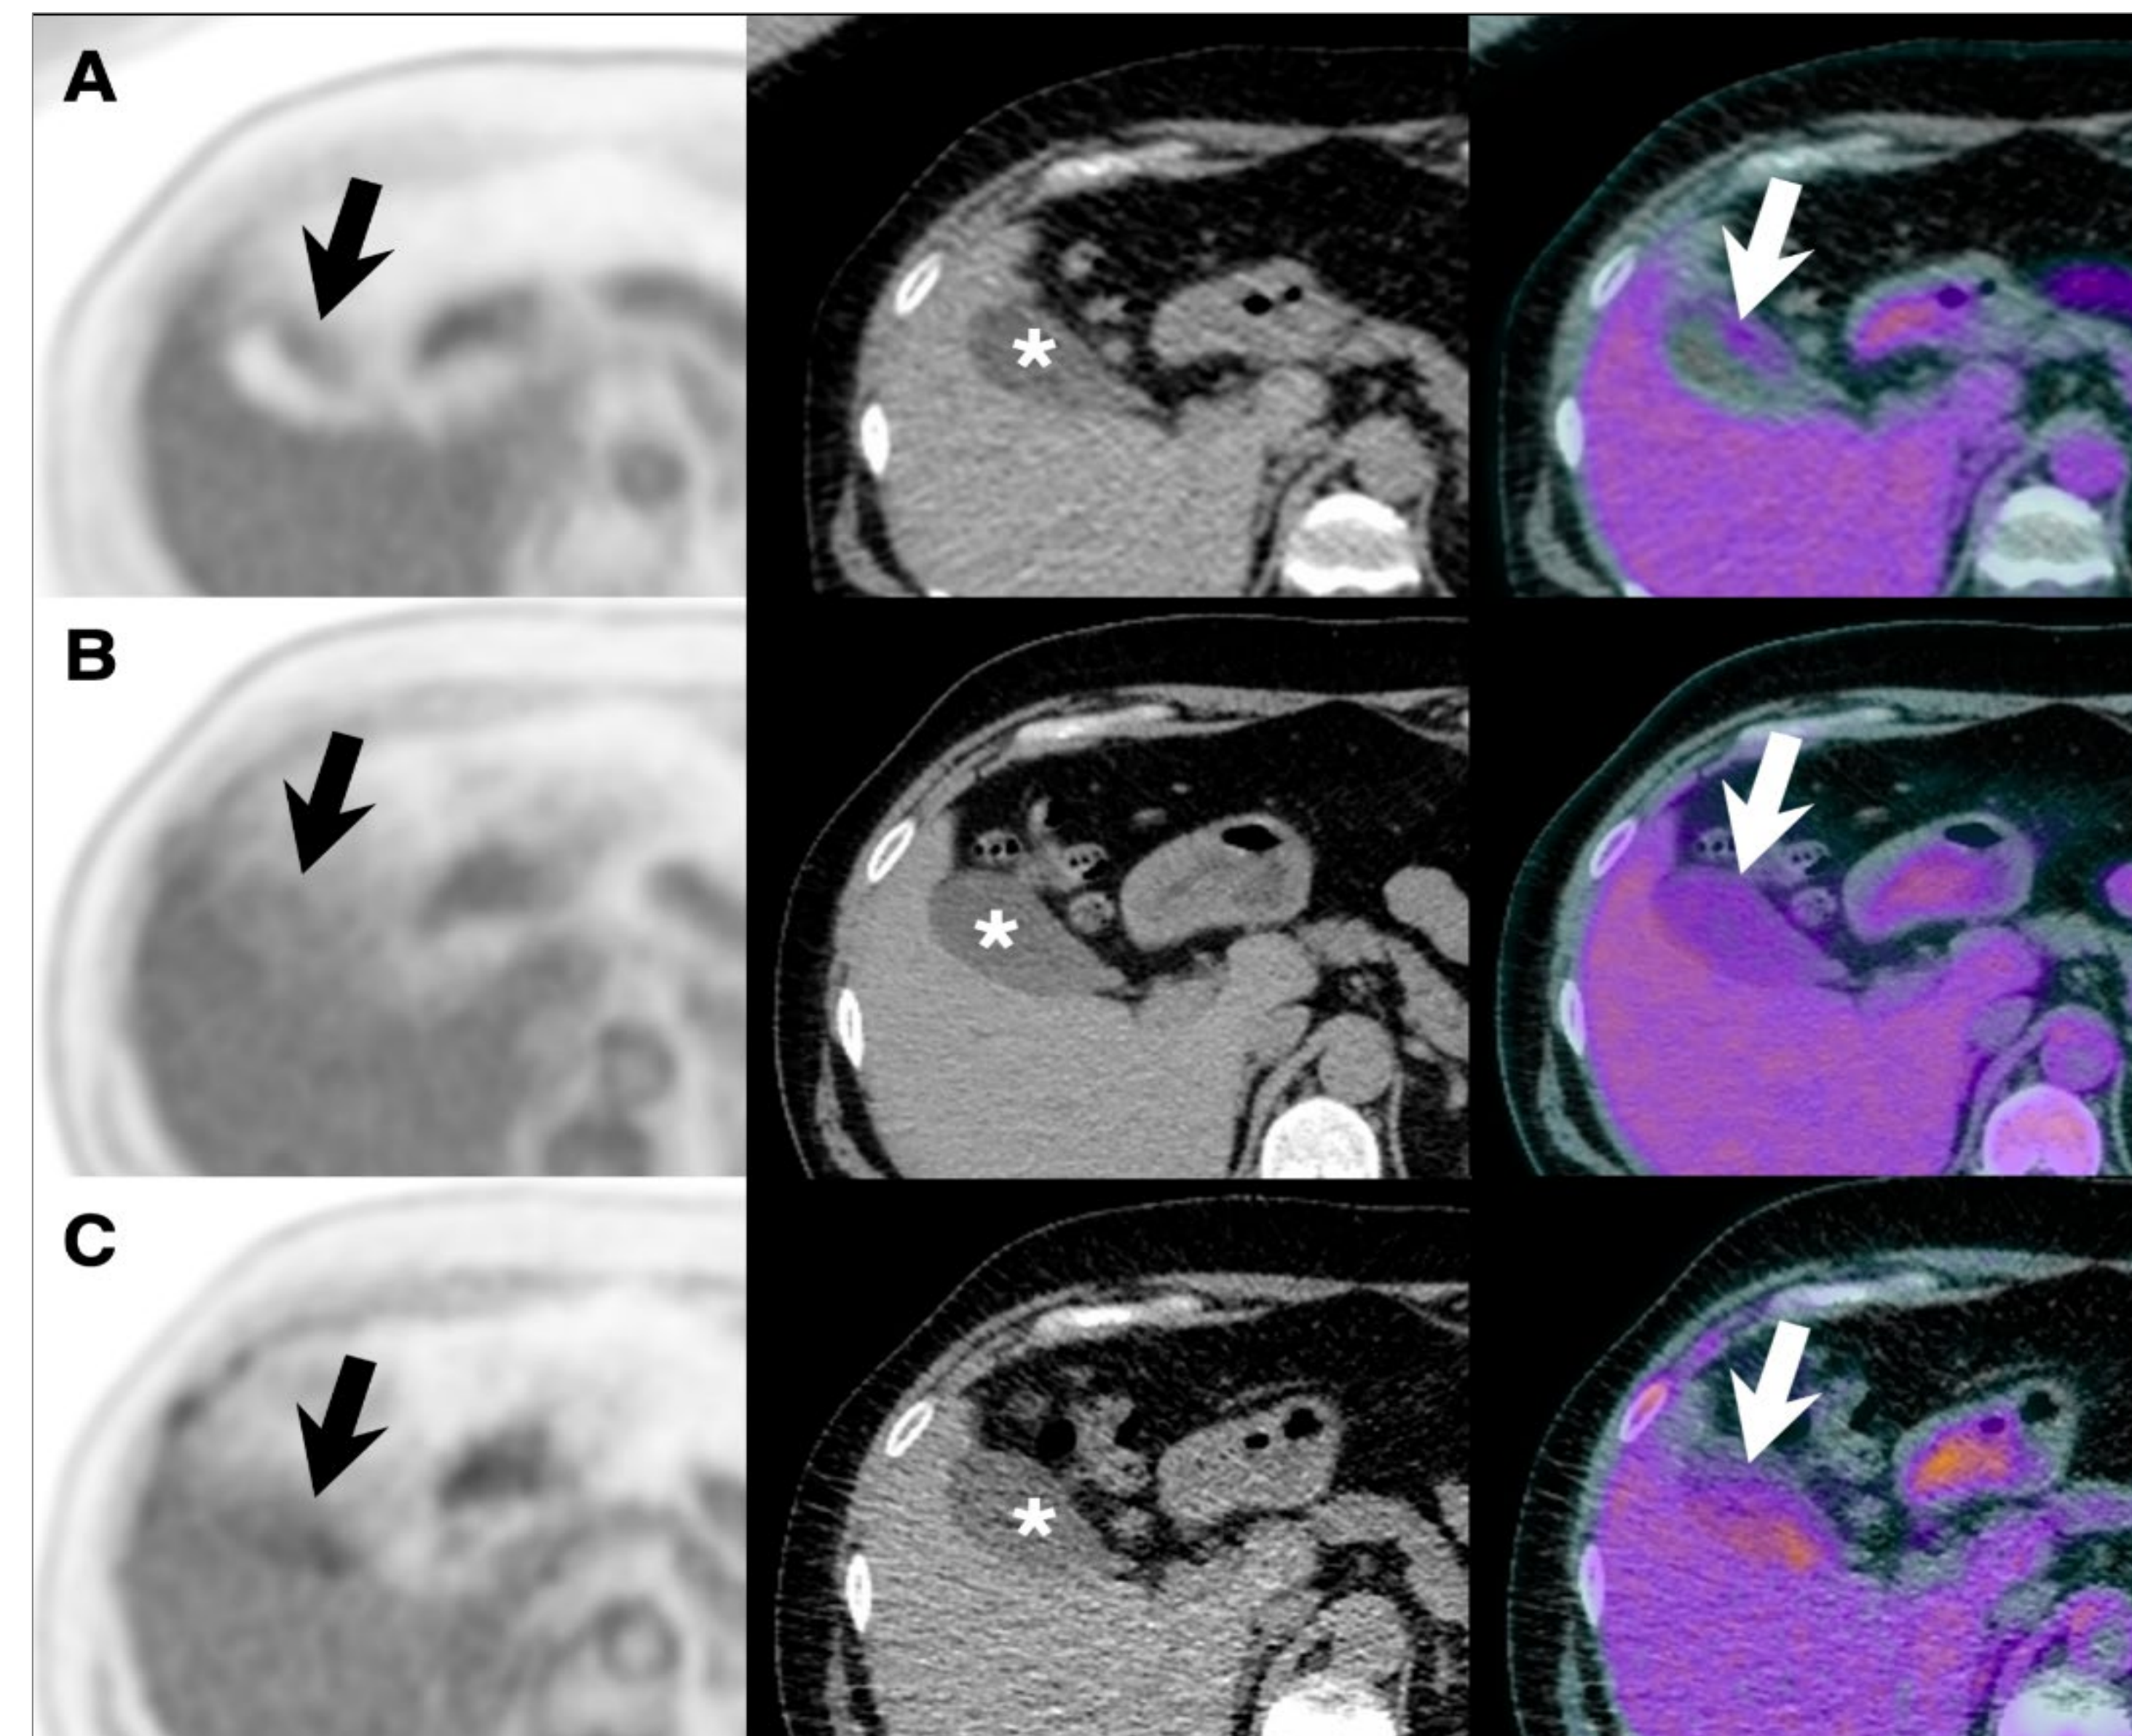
Changes in the intensity and pattern of gallbladder ¹⁸F-FDG uptake on serial total-body PET/CT acquisitions. Axial PET, CT and fused images acquired after i.v. injection of 389 MBq in a 53 y/o healthy female participant. (A) images at 40-minute timepoint showing wall activity, equal to the liver background; (B) images at 90-minute timepoint showing luminal uptake, equal to the liver uptake; and (C) images acquired at 180-minute post-injection showing increased luminal uptake, higher than that of the liver background. The gallbladder lumen is indicated by an asterisk (*) in the CT images.
